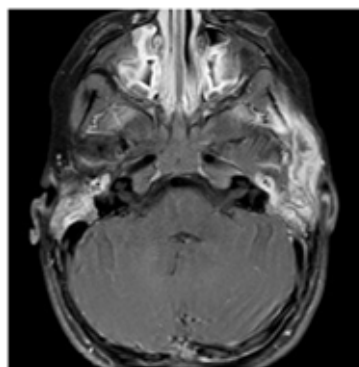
Magnetic resonance imaging (MRI) after 9 months of treatment. T1 sequence. No evidence of ear lesions can be detected.
